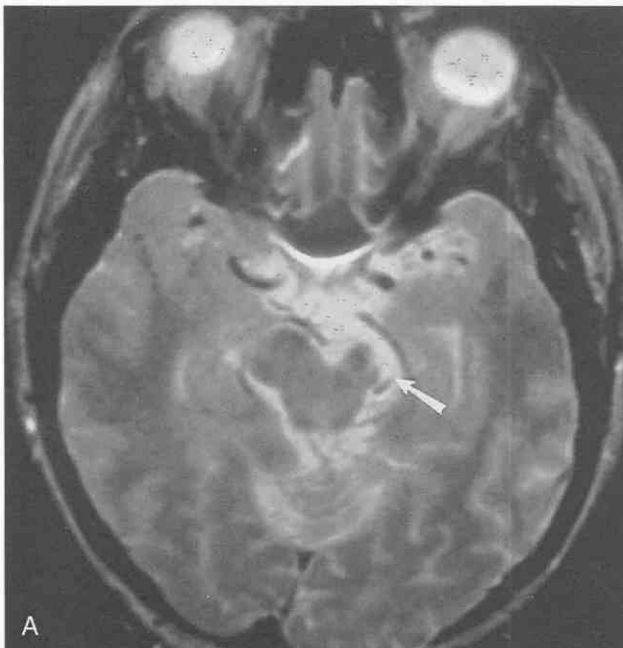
Wallerian degeneration. A, Axial T2-weighted MR image shows the left cerebral peduncle to be of decreased size and increased signal intensity (*arrow*). B, T2-weighted image located more superiorly shows evidence of old middle cerebral artery territory infarction. Axonal degeneration is thought to produce the remote subcortical changes.
